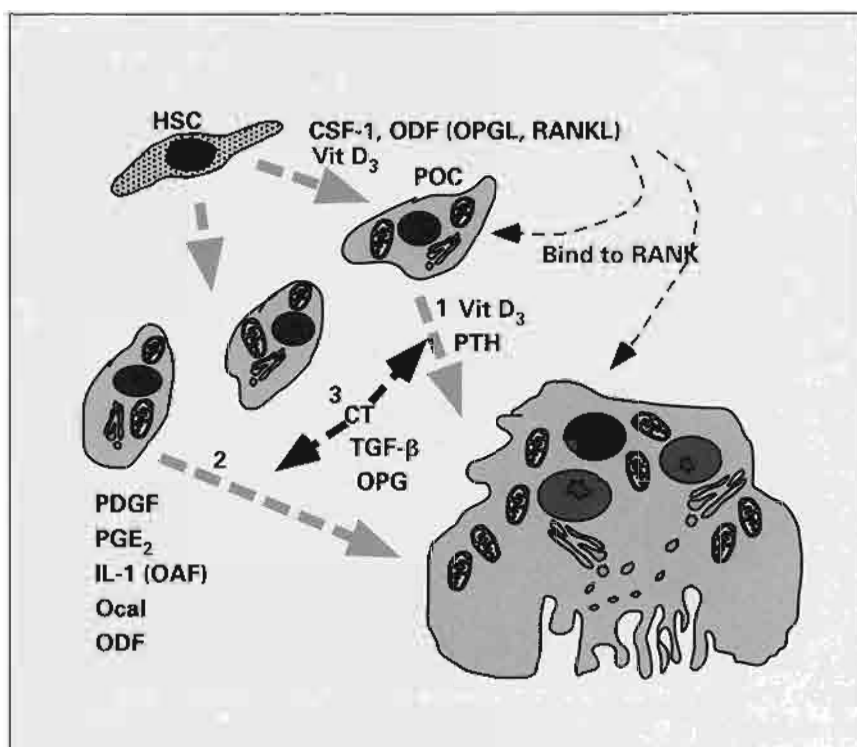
Development of a preosteoclast (POC) from hematopoietic stem cells (HSC) under the influence of monocyte colony-stimulating factor 1 (CSF-1) and 1,25-dihydroxy-vitamin D₃ (Vit D₃). Systemically acting substances, such as platelet-derived growth factor (PDGF), prostaglandin E₂ (PGE₂), and osteoclast-activating factor (OAF), stimulate the formation of multinucleated osteoclasts from circulating mononuclear preosteoclasts. Osteocalcin (Ocal), present in mineralized bone, is necessary for osteoclast formation. Calcitonin (CT) and transforming growth factor β (TGF- β) act to block the formation of osteoclasts. (IL-1) Interleukin 1; (ODF) osteoclast differentiation factor; (OPGL) osteoprotegerin ligand; (PTH) parathyroid hormone; (RANK) receptor activator of nuclear factor κ B; (RANKL) receptor activator of nuclear factor κ B ligand.
